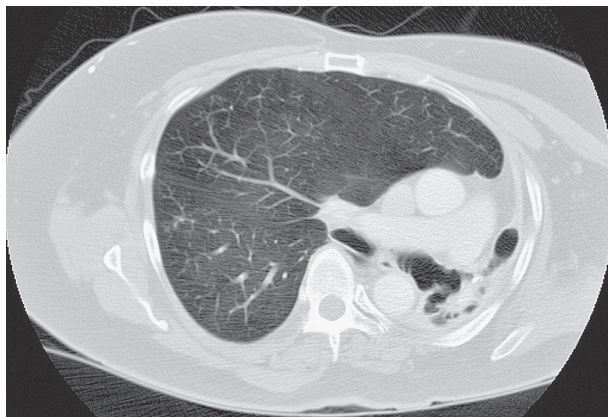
■ Computed tomography scan demonstrating end-stage bronchiectasis involving the left lung, with complete parenchymal destruction.
